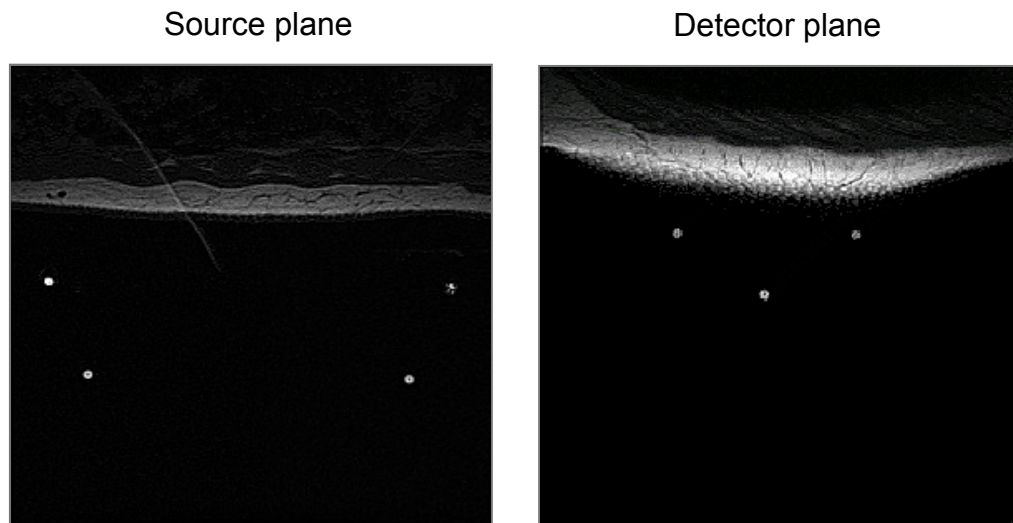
Appearance of the compression plates' fiducial markers on MR images.
